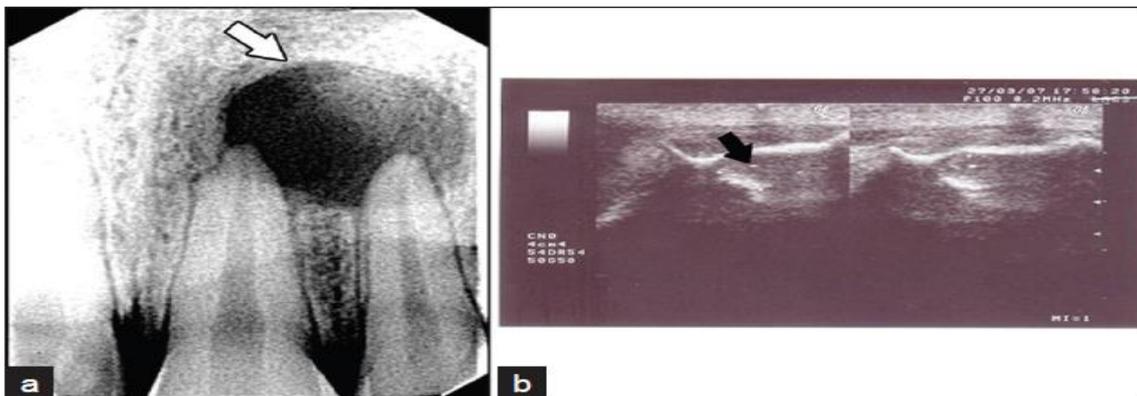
(a-b) Radiovisiographic (RVG) and Ultrasound (US) images of a periapical lesion (1a) RVG image shows a well-circumscribed, radiolucent, periapical lesion with a sclerotic border, measuring about 2 x 1 cm in diameter (white arrow) (1b) USG shows a hypoechoic, well-contoured cavity, with no evidence of internal vasculature (Black arrow).^[1]
